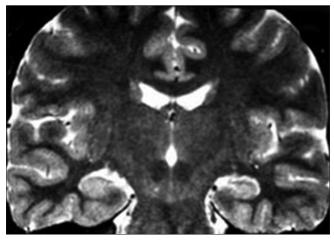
Coronal T2-weighted MRI in a 30.5-year-old woman affected by non-classic CAH. The right hippocampus is moderately round-shaped and its internal structures are not identified (patient no. 21)
